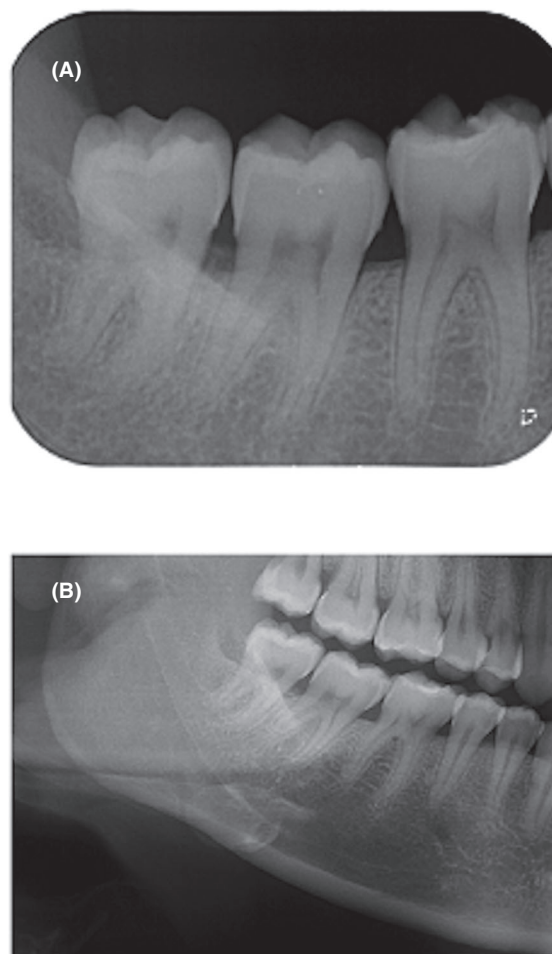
Conventional imaging: (A) Periapical radiograph showing no alterations (B) Panoramic radiograph indicating an enlargement of the mandibular canal in the third molar area.
